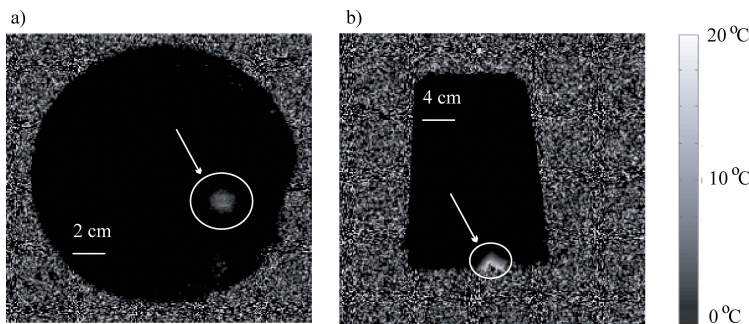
MR-temperature maps of the coronal (a) and sagittal (b) plane, showing the time point with the greatest temperature rise during the application of ultrasound.
